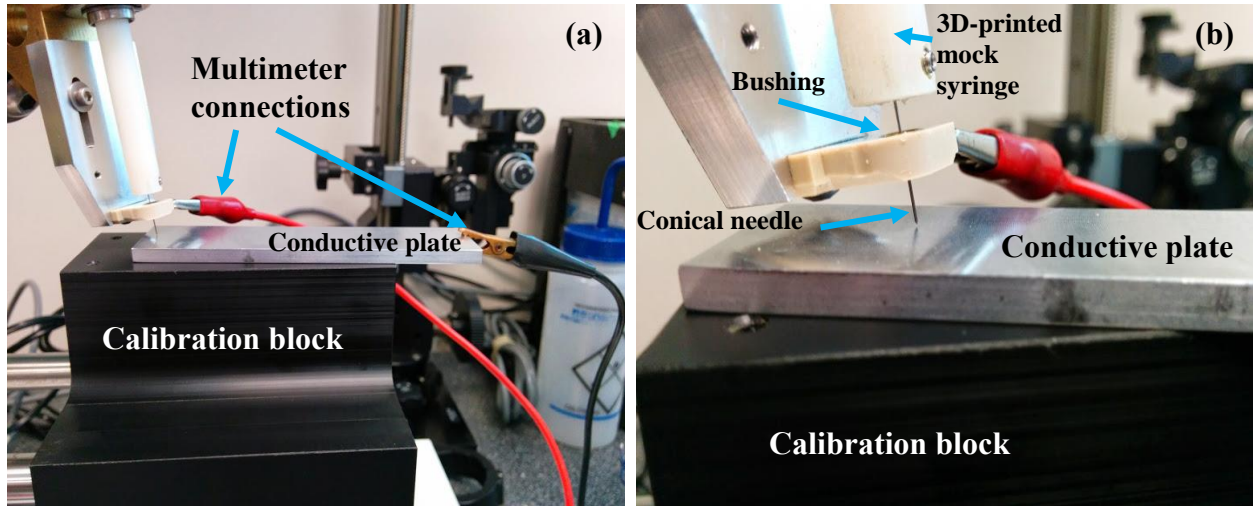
Overview of RCM needle calibration technique developed for the ultrasound-guided device. The top surface of the conductive plate meets the RCM point. Contact between the needle tip and plate is detected by a multimeter. The closed circuit path is such: multimeter → brass bushing → steel needle → aluminum plate → multimeter.
